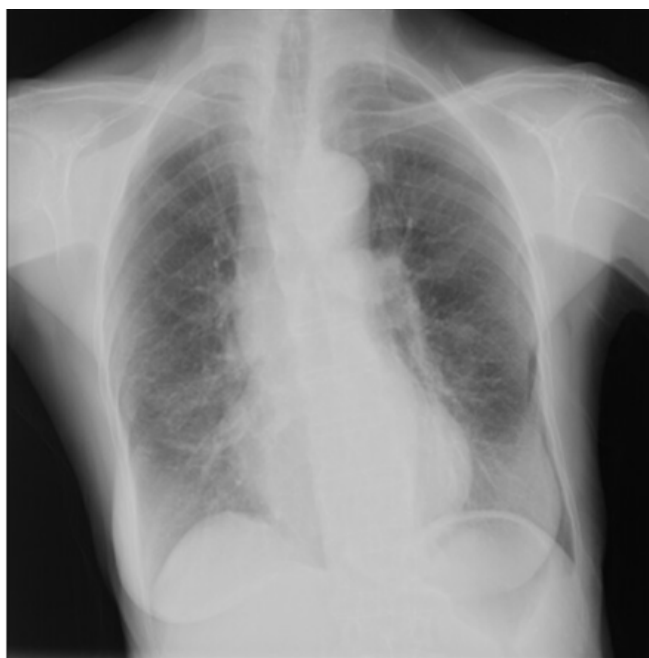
Chest radiograph following completion of 12 months of antimycobacterial therapy. There is partial resolution of the previously noted infiltrates and no evidence of progression. Bronchial markings remain prominent, consistent with stable underlying bronchiectasis.
